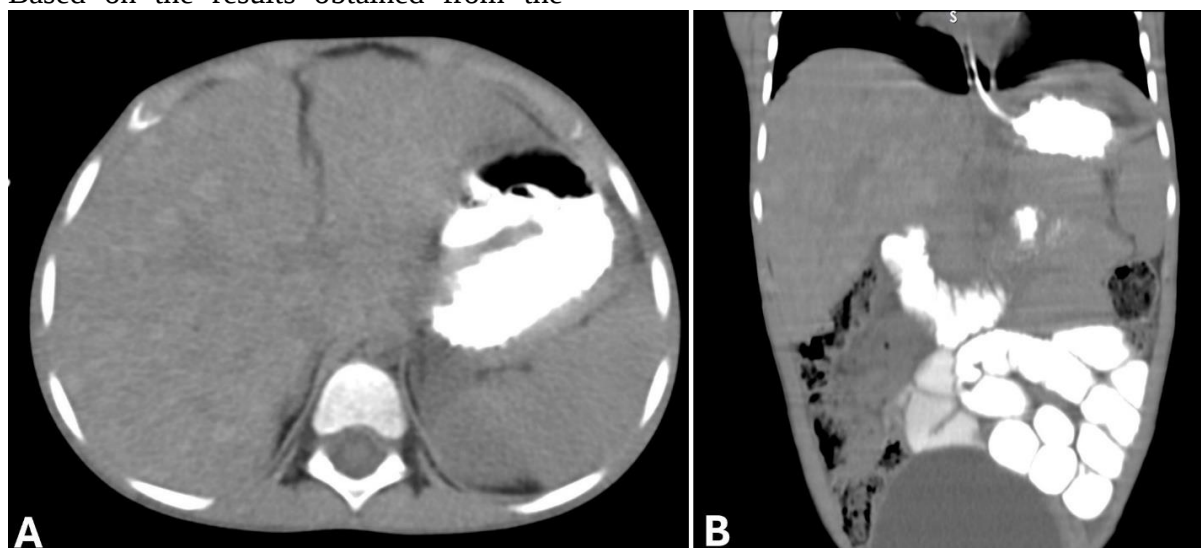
CT scan of abdominal organs in transverse (A) and coronal (B) views. The liver is heterogeneous and contains multiple nodules throughout the liver and small hypodense foci.
